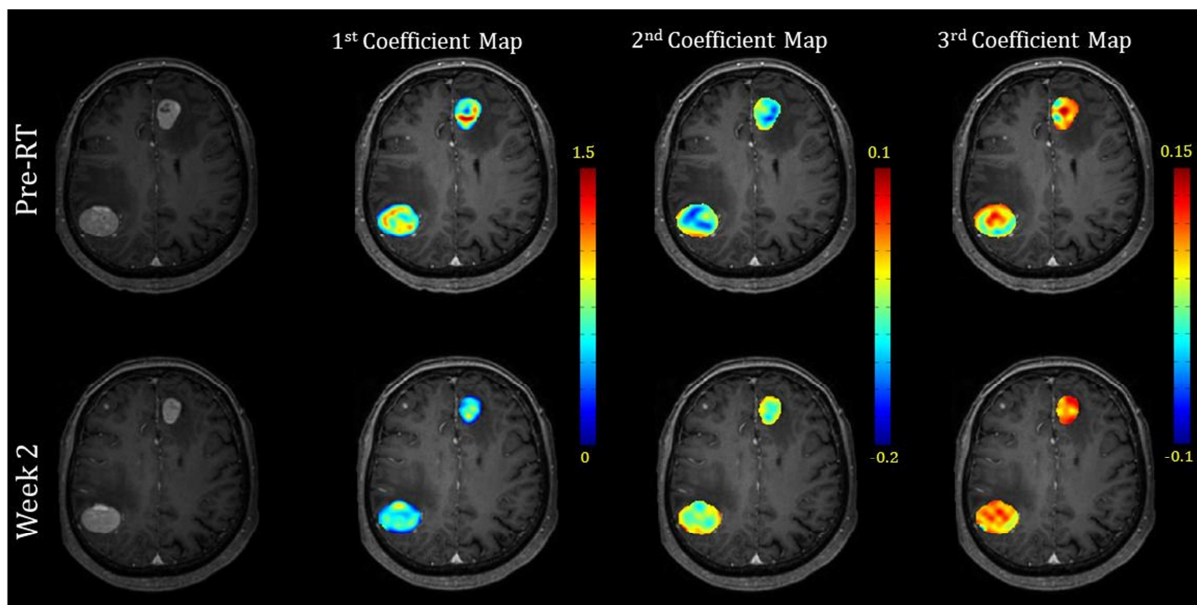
Distribution patterns of the first three projection coefficient maps in tumors overlaid on T1-weighted images pre-RT and week 2 after start of whole brain radiotherapy.
